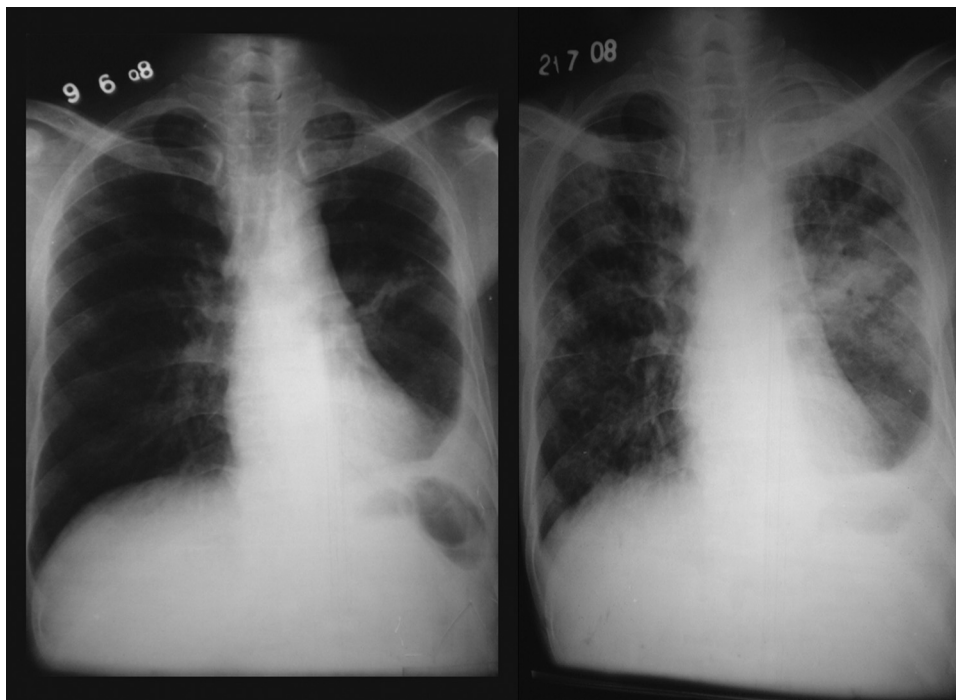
Pulmonary TB IRD. The images are X-ray radiographs for a male patient (aged 38 years) displaying a parenchymal lesion in the left lung/left midzone and left pleural effusion when initiated on ART 6 weeks after starting TB therapy (left). Exacerbation of clinical symptoms after 3 weeks coincided with increased pulmonary infiltrates (right).
